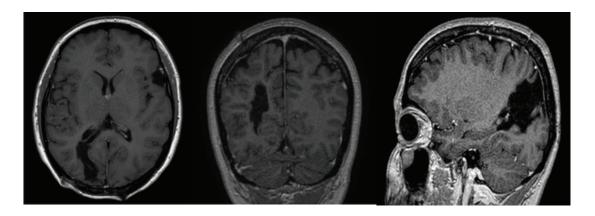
Post-operative brain MRI in axial, coronal, and sagittal sections showing complete resection of the lesion.
